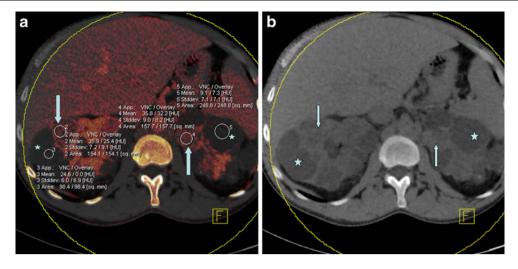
Dual energy CT in a 40-year-old man with known autosomal dominant polycystic kidney disease (ADPKD) allows for direct visualisation of contrast enhancement based on a single-phase CT examination. Colour-coded image (a) shows the absence of enhancement in two simple cysts (*asterisks*), whereas two malignant-appearing masses
